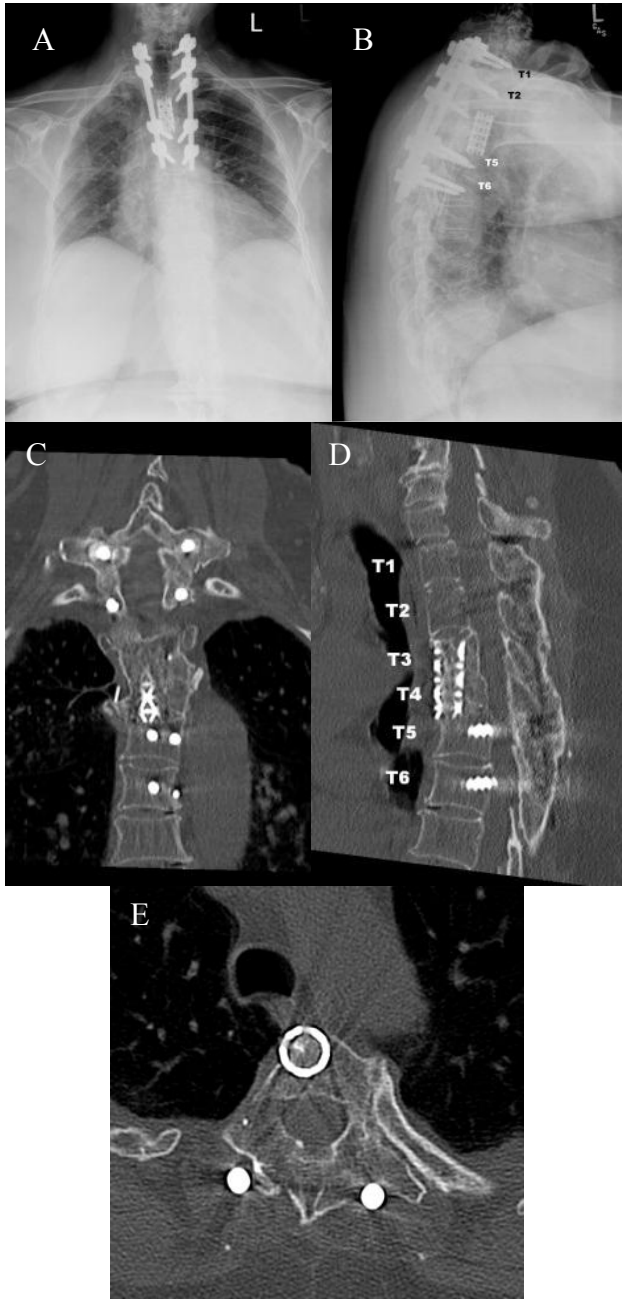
Five-year postoperative images. The AP (A) and lateral (B) show no hardware loosening and maintained kyphotic angle at 23 degrees. The CT scan images (coronal, C; sagittal, D and axial, E) show evidence of solid fusion.
